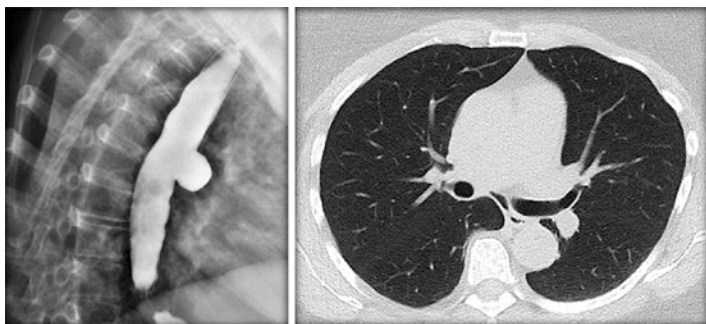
Esophagram and non-contrast CT scan of the chest demonstrating an anterolateral esophageal diverticulum
